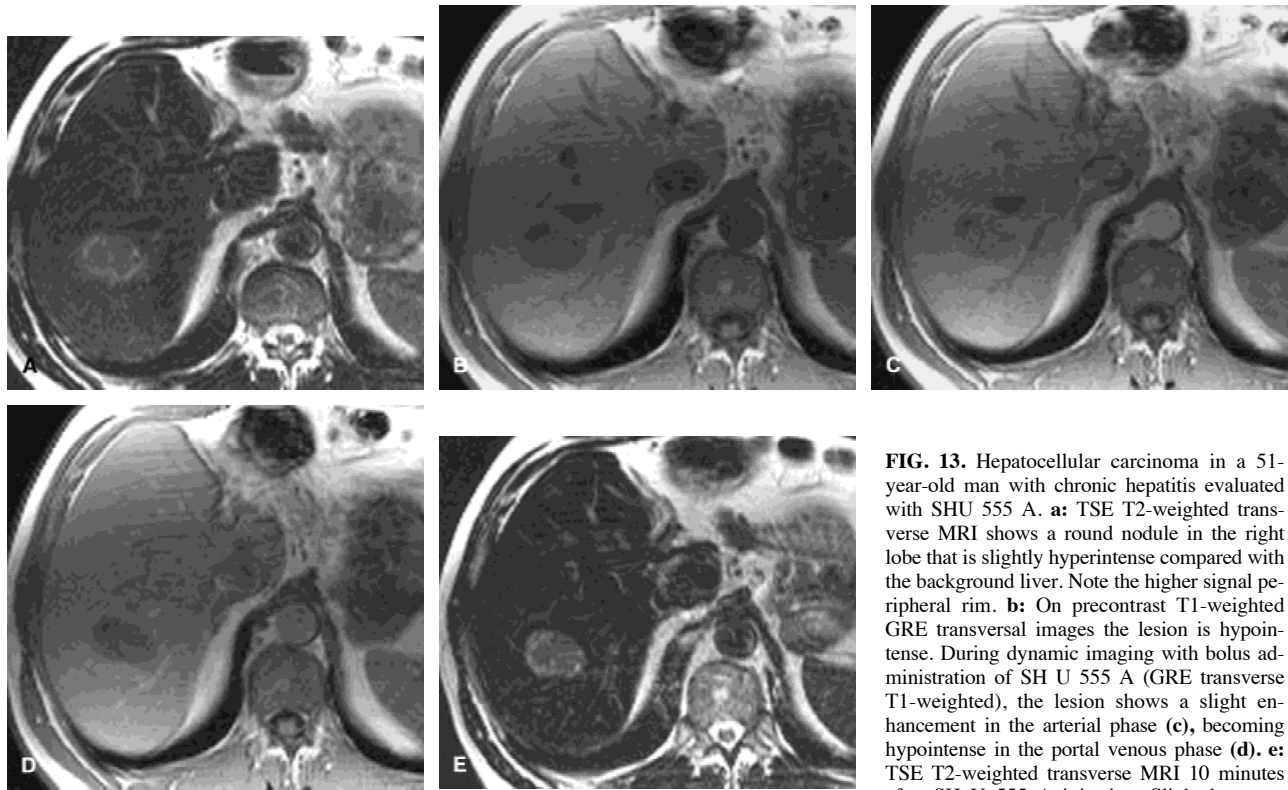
Hepatocellular carcinoma in a 51-year-old man with chronic hepatitis evaluated with SHU 555 A. a: TSE T2-weighted transverse MRI shows a round nodule in the right lobe that is slightly hyperintense compared with the background liver. Note the higher signal peripheral rim. b: On precontrast T1-weighted GRE transversal images the lesion is hypointense. During dynamic imaging with bolus administration of SH U 555 A (GRE transverse T1-weighted), the lesion shows a slight enhancement in the arterial phase (c), becoming hypointense in the portal venous phase (d). e: TSE T2-weighted transverse MRI 10 minutes after SH U 555 A injection. Slight homogeneous
